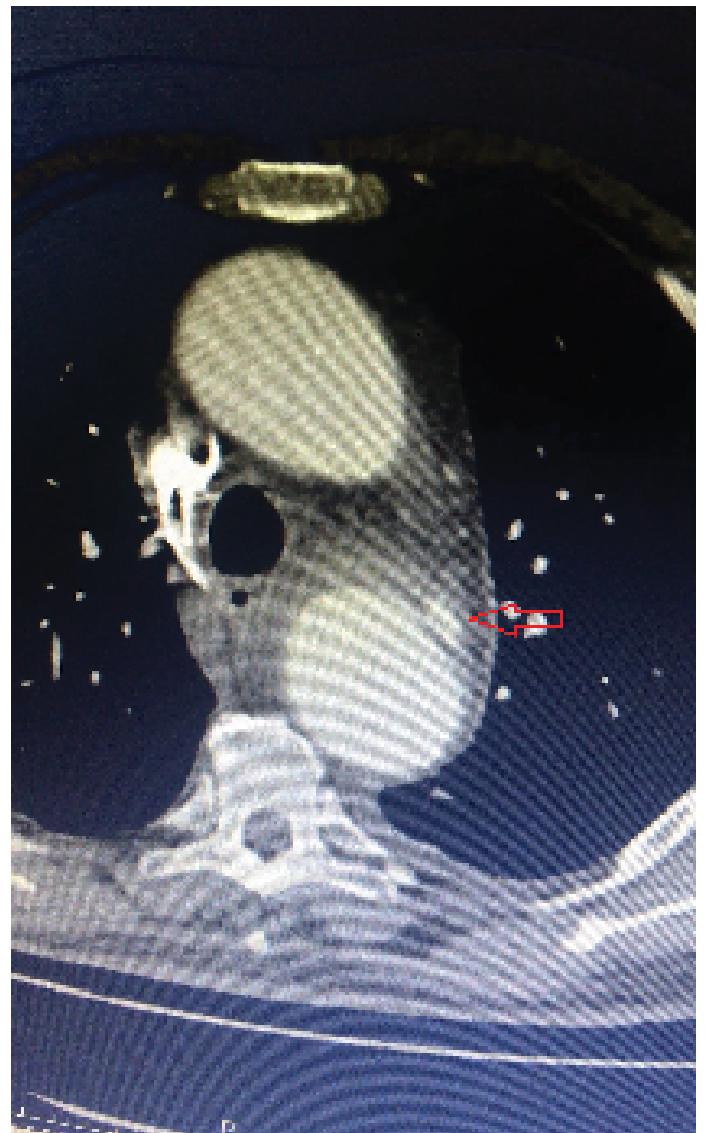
Preoperative CT image of impending rupture
